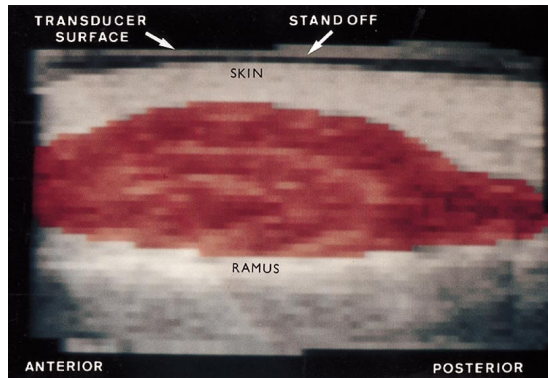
Ultrasound image of masseter registered using a single scan sweep. A small section of the muscle has not been imaged due to the probe being of inadequate width.
